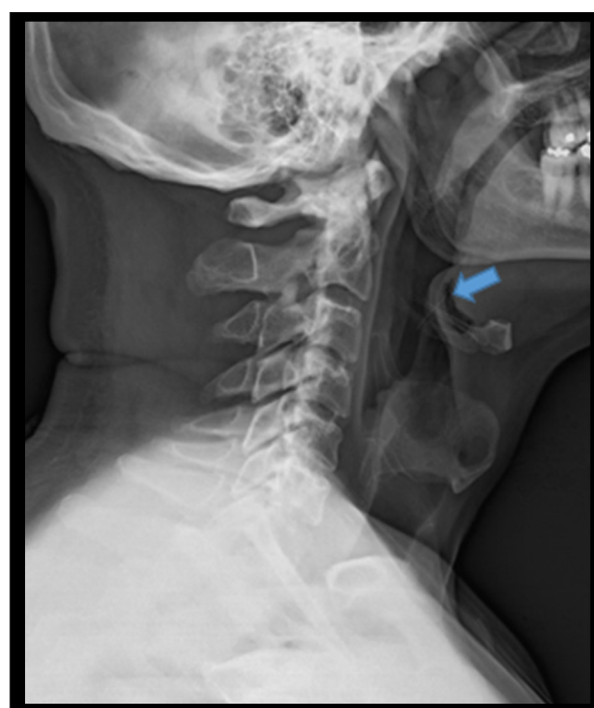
Case 3 – X-ray of the neck suggestive of a small metallic foreign body (blue arrow).
